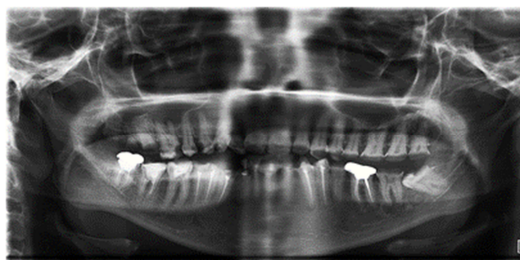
A post-operative orthopantomogram showing completed endodontic treatment of seven teeth
